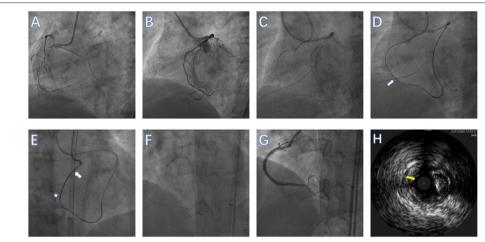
Performing Guidezilla<sup>TM</sup> reverse controlled antegrade and retrograde subintimal tracking (CART) during rotational atherectomy (RA) in a right coronary artery (RCA) CTO lesion. (A) RCA in left anterior oblique view showing an ambiguous proximal cap without obvious calcification. (B) RCA in left anterior oblique view showing the distal cap of the RCA. (C) Antegrade wire in the subadventitial space of mid-RCA. (D) The CTO lesion was crossed over using the Guidezilla<sup>TM</sup> reverse CART technique (the white arrow represents the dilated balloon). (E) Retrograde wire (white arrow) was advanced into the Guidezilla<sup>TM</sup> (white star) of the RCA and externalized. (F) Rotational atherectomy was then performed using a 1.25-mm burr. (G) Angiography after successful CTO-PCI. (H) Intravascular ultrasound confirmed that the guidewire (yellow arrow) was in the subadventitial space (The white dotted line represents the true lumen of the vessel).
